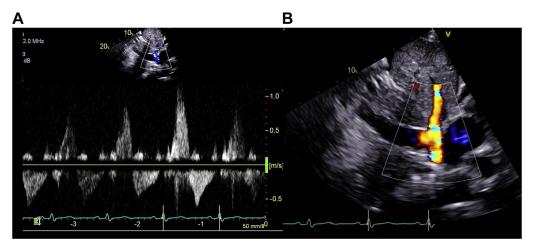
Two-dimensional TTE oriented in a subcostal view with pulsed-wave Doppler (A) and color flow Doppler (B) demonstrating hepatic vein systolic flow reversal consistent with severe TR.
